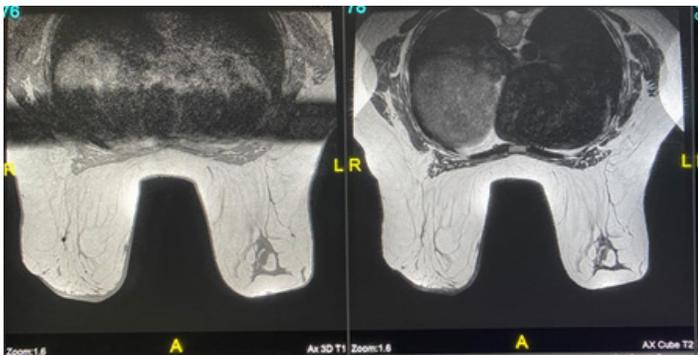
MRI-Axial T1 and T2 WI showing irregular area in the left breast at 12 o'clock position, showing low signal on T1 and T2 WI and intervening small areas following fat signal
